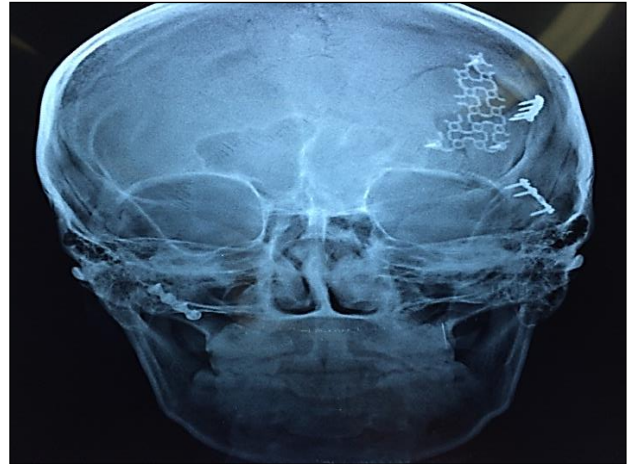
Patient 4 post-op radiograph showing fracture fixed with titanium mesh.
